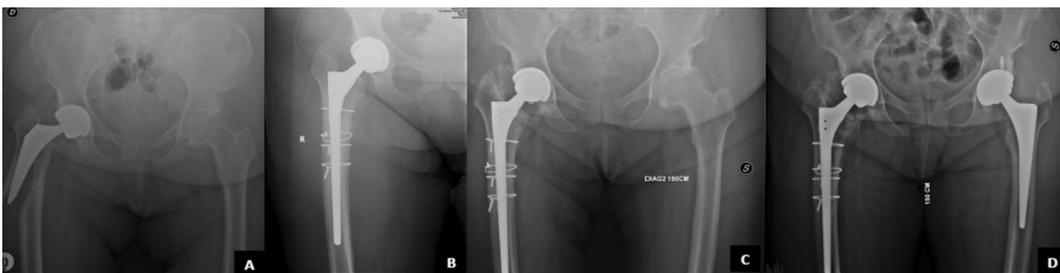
Example of B2 PPF. a Preoperative AP pelvis X-ray. b Postoperative X-ray showing stem revision and synthesis with cerclage wires. c One-year follow-up. d Two-year follow-up. Postoperative X-ray shows minimal subsidence, however, with very good clinical functional outcome
